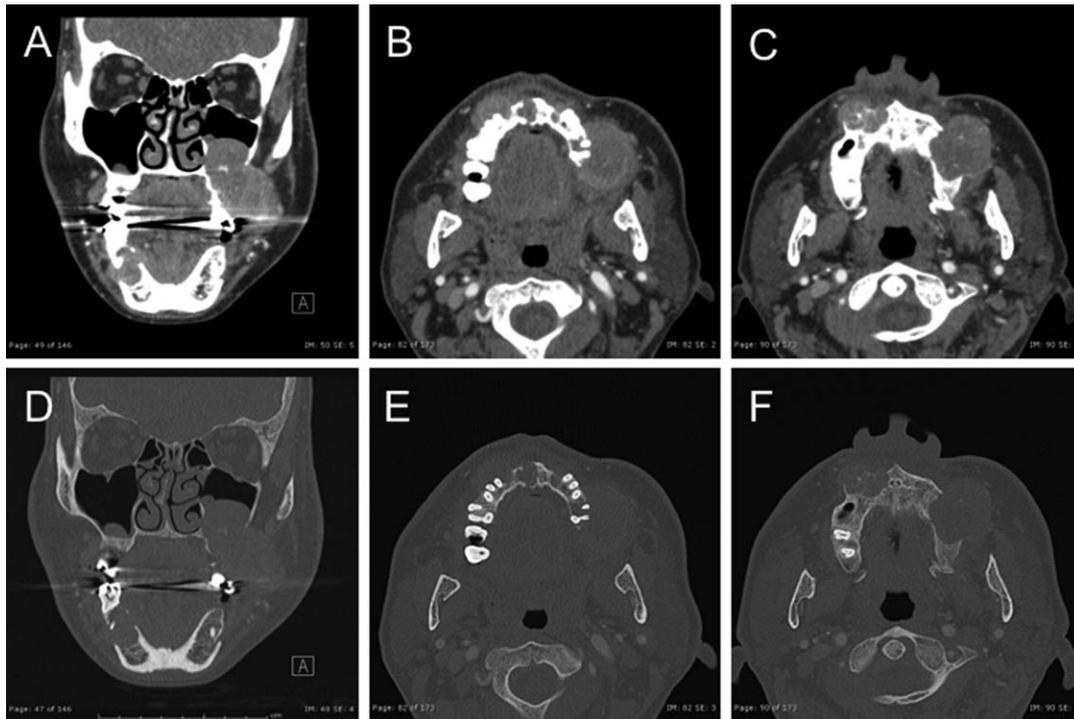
Facial computed tomography with contrast. Coronal (A, D) and axial (B, C, E, F) sections demonstrate multiple mandibular and maxillary expansive, lucent enhancing lesions with extrasosseous extension, and some with internal matrix calcification (A, D). (A–C) Soft tissue windowed. (D–F) Windowed for bone. With a multifocal presentation, the differential diagnosis may include metastases, myeloma with plasmacytomas, multiple odontogenic tumors, or brown tumors (osteitis fibrosa cystica).
